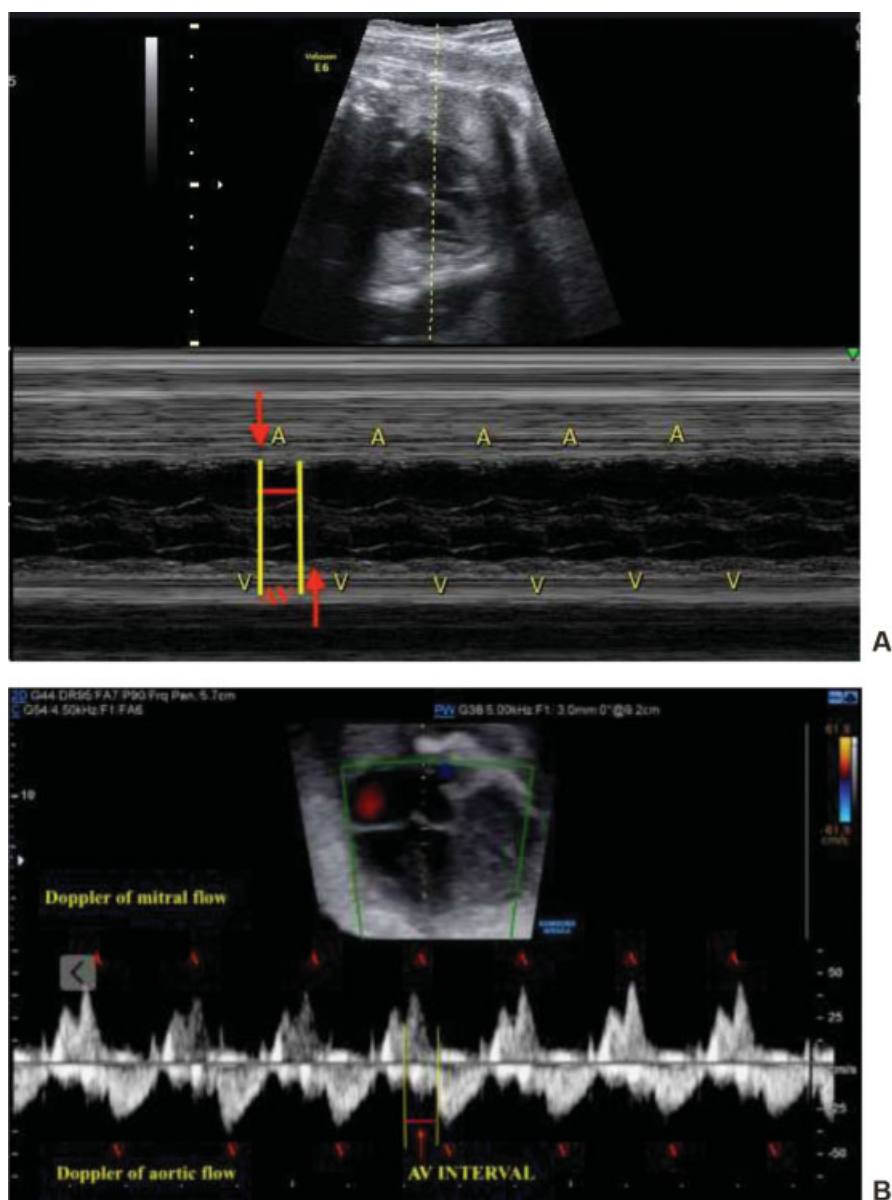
Assessment of the atrioventricular interval time (AV interval, which is analogous to the electrical PR interval) by fetal echocardiogram: M-mode ultrasound (A) and Doppler of the mitral and aortic flow (B). Abbreviations: A: atrial contraction; V: ventricular contraction.
